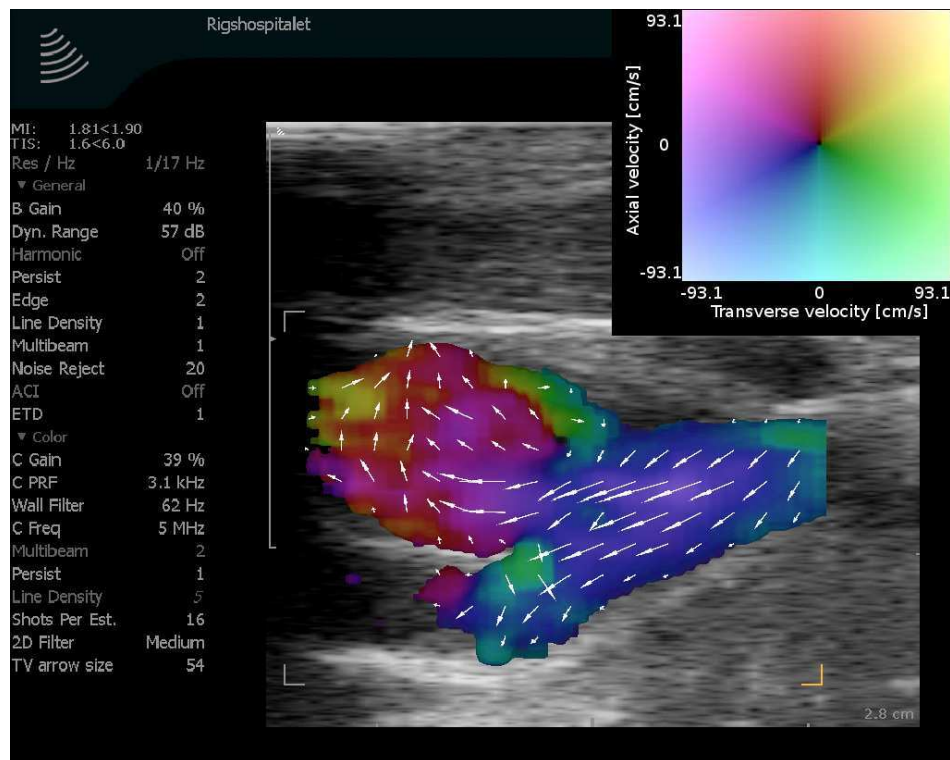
Vector flow ultrasound of the carotid bifurcation including the common carotid artery (right), and the carotid bulb (top left) with clearly different flow patterns.*
